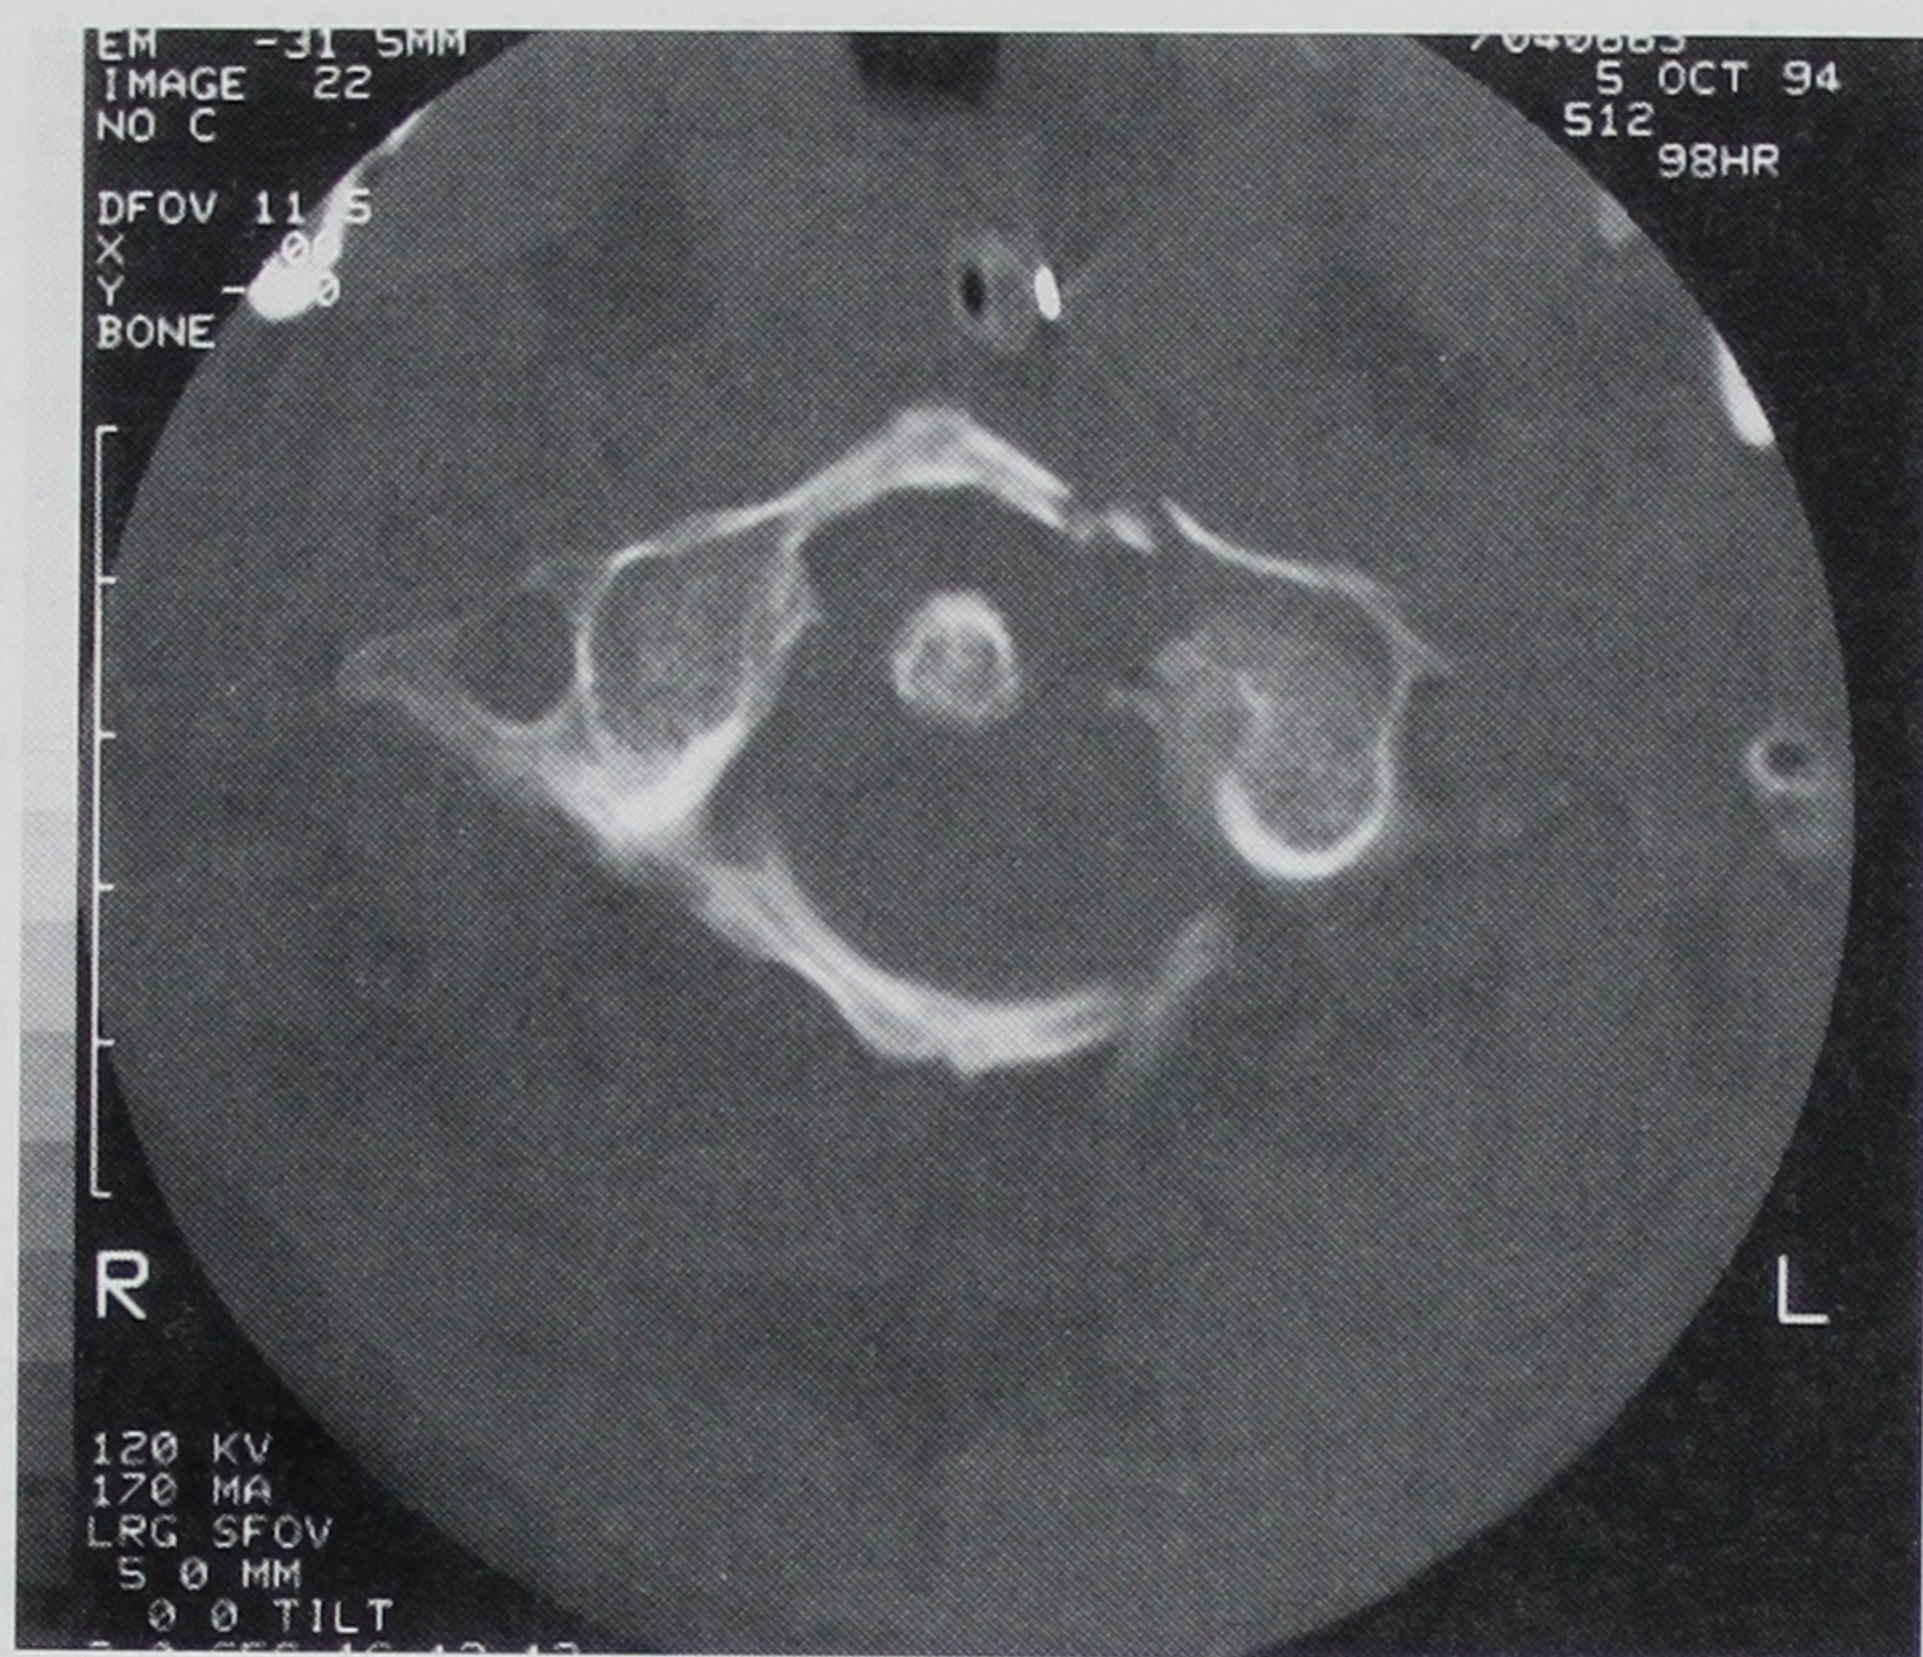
Preoperative axial computed tomographic scan showing a 7-mm preodontoid interval. The patient sustained a Type III Jefferson fracture associated with a Type II odontoid fracture. A posterior C1–C2 fusion was performed, and the patient remained in a rigid collar for 10 weeks after surgery.
